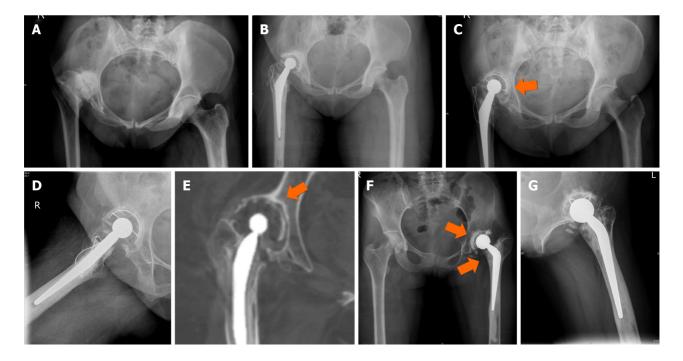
High hip centre/inadequate restoration of hip centre at total hip arthroplasty. A and B: Proximal and lateral migrated dysplastic hip after total hip arthroplasty (THA) with high hip centre. Greater trochanter fracture at reduction stabilised with wiring; C-E: 15-year follow-up with symptomatic acetabular loosening confirmed with computed tomography assessment. This required acetabular revision with hip centre restoration with augments; F and G: Dysplastic hip with cemented THA at 6 years follow-up -proximal and lateralised acetabulum, with reduced neck length and offset femur. Shortening, limp and pain required revision in this hip with acetabular loosening(arrows). Restoration of hip centre, offset was done with true acetabular floor identification, small component, soft tissue release and femur revision.
